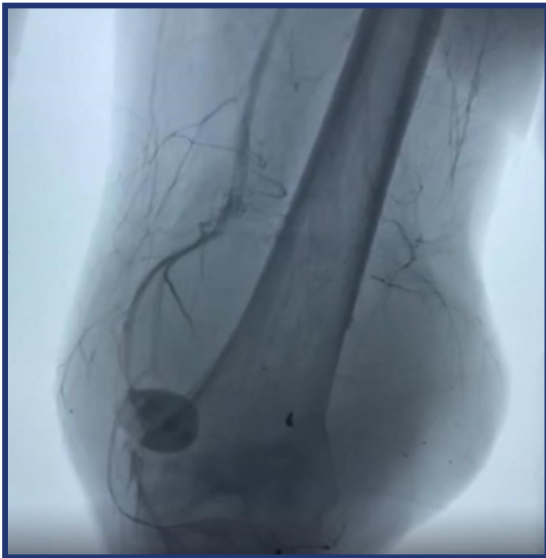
Angiotomography in simple plane of radiographic reconstruction showing a left suprapatellar mass.
